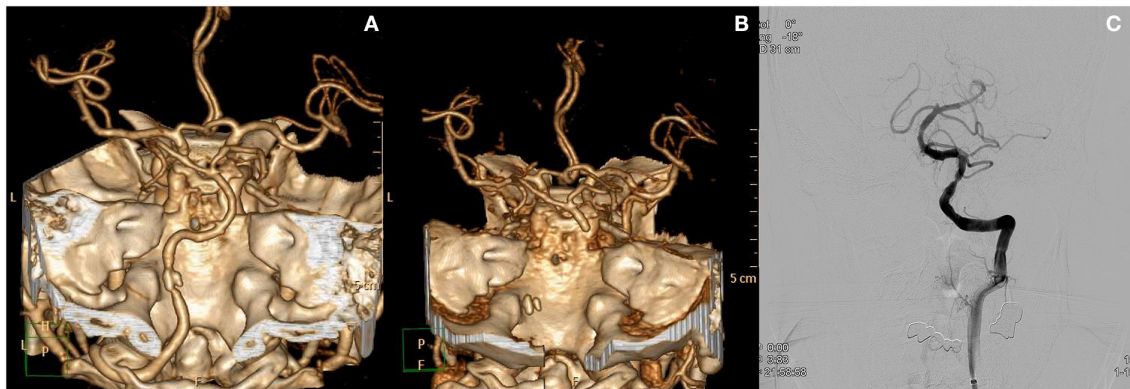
Case of a patient who presented with prodromal acute vestibular syndrome. (A) Initial CT angiography revealed focal calcified plaque at the left distal vertebral artery with stenosis. The patient was discharged from the ED. Three days later, the patient revisited the ED with newly onset major neurological deficits. (B) CT angiography at that time show occlusion from the left vertebral artery to the distal basilar artery. (C) Recanalization of basilar and vertebral arteries after endovascular treatment.
